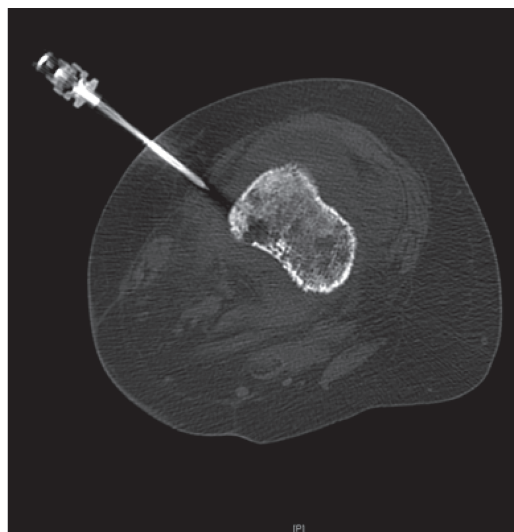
Axial computed tomographic scans from bone biopsy performed in interventional radiology.
